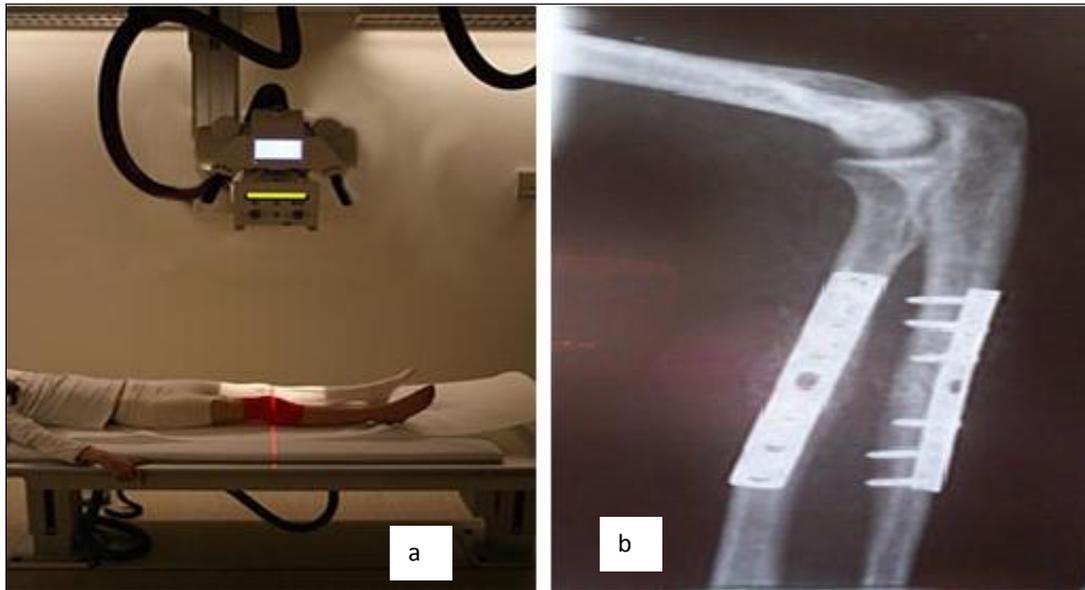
a. Radiography to identify eventual bone fractures after a knee injury. b. Orthopaedic implants to repair fractures to the radius and ulna.
